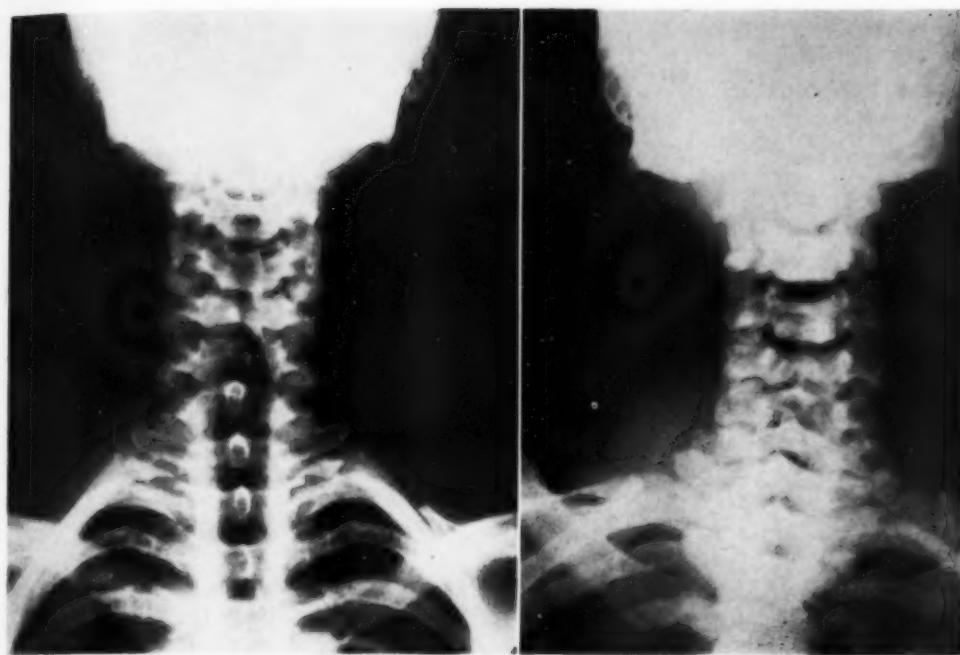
Roentgenogram of a normal cervical spine (left) compared with the patient's (right). The thickened trabeculae in fluoride osteosclerosis produced a marked increase over the normal bone density.
